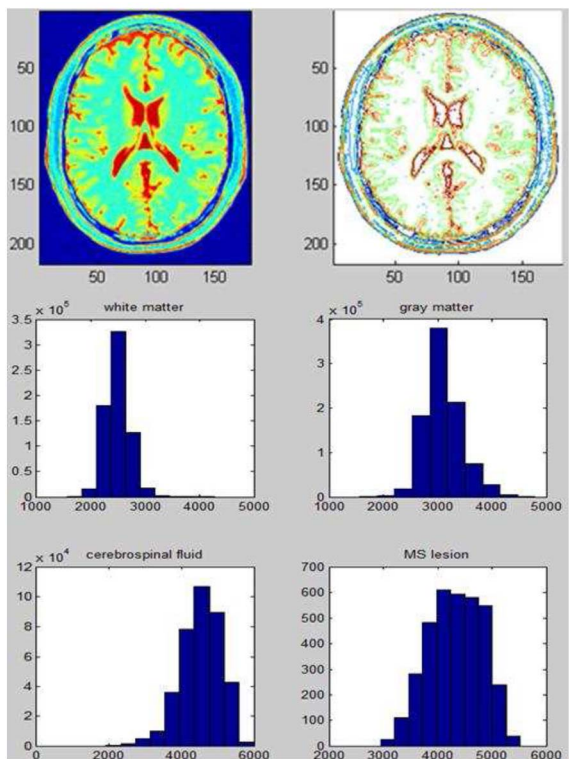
A T2-w MRI image with its contour plot and intensity histograms of WM, GM, CSF and MS lesions.
